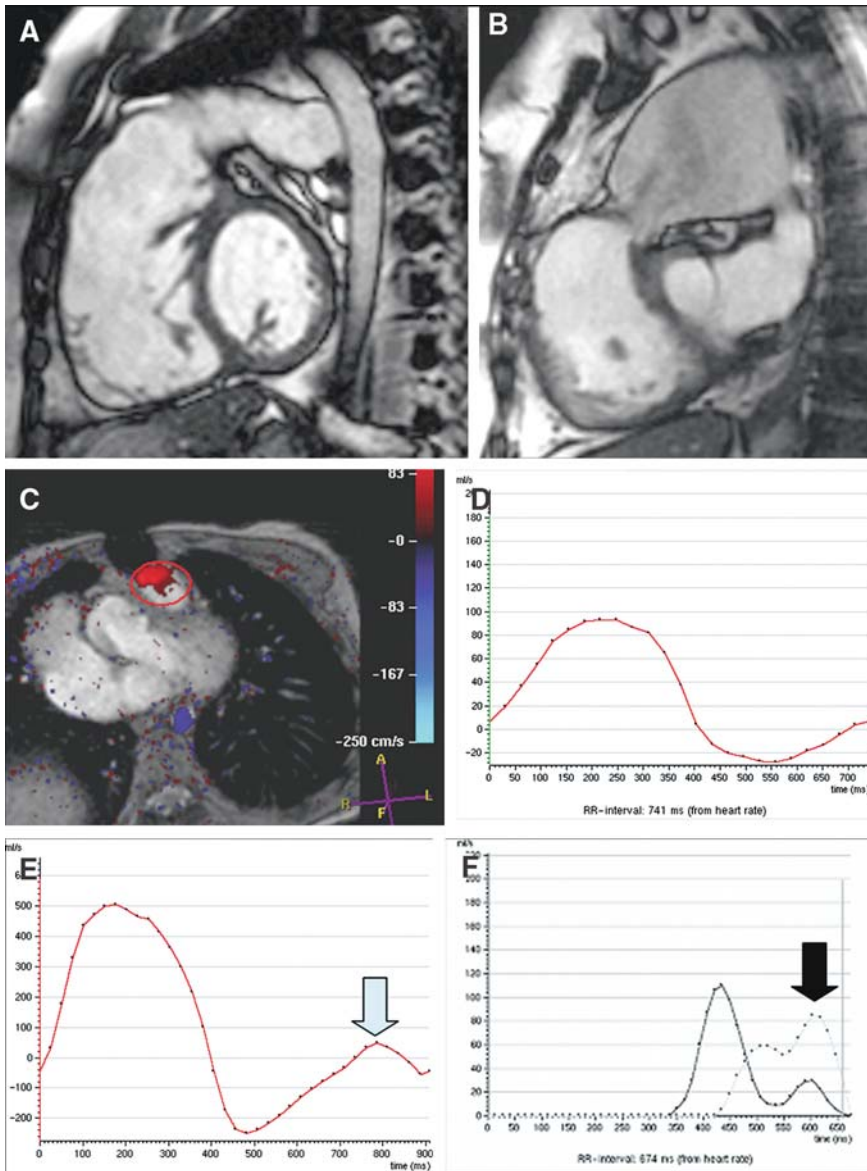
shows MRI for evaluation of the systemic right ventricle after intra-atrial repair of d-transposition of the great arteries.
